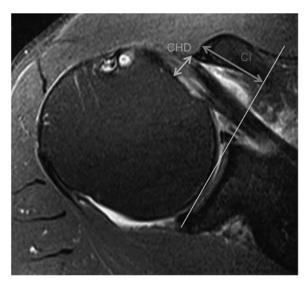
Magnetic resonance imaging of a male left shoulder showing narrowed coracohumeral distance (7 mm, small arrow) and increased coracoid index (CI, 20 mm, large arrow) in patient with partial subscapularis tendon tear, biceps-tendon rupture, and a cyst within the lesser tuberosity.
